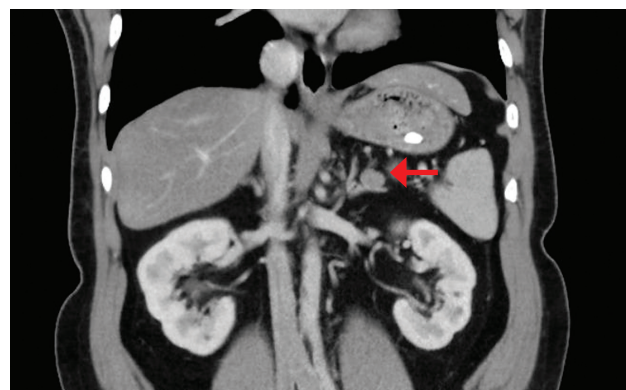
Left adrenal nodule (red arrow) as seen on CT adrenal in coronal view.
